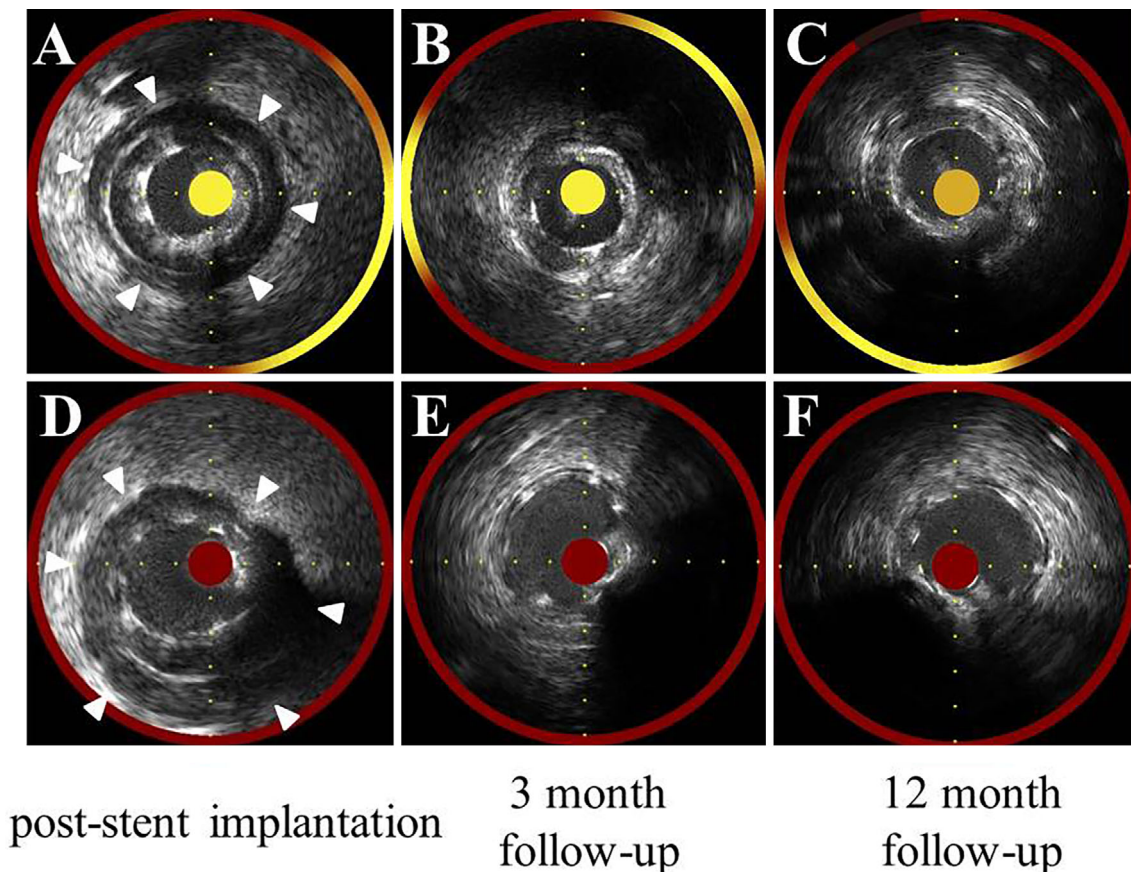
(A) Near-infrared spectroscopy intravascular ultrasound (NIRS-IVUS) imaging immediately after stent implantation of the left circumflex artery (LCX) showed a low-echoic region on the outer side of the media (white arrowheads). (B) NIRS-IVUS imaging 3 months after treatment of the LCX showed a markedly reduced low-echoic region on the outer side of media. (C) The reduced low-echoic region persisted after 12 months' treatment according to NIRS-IVUS imaging. (D) NIRS-IVUS imaging immediately after stent implantation of the right coronary artery (RCA) showed a low-echoic region on the outer side of the media (white arrowheads). (E) NIRS-IVUS imaging 3 months after treatment of the RCA showed a markedly reduced low-echoic region on the outer side of media. (F) The reduced low-echoic region persisted after 12 months of treatment according to NIRS-IVUS imaging.
